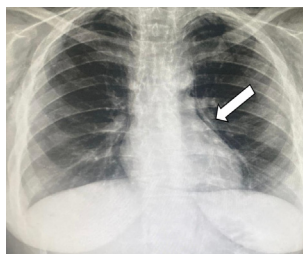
Chest X-ray showing pneumomediastinum and subcutaneous emphysema.
